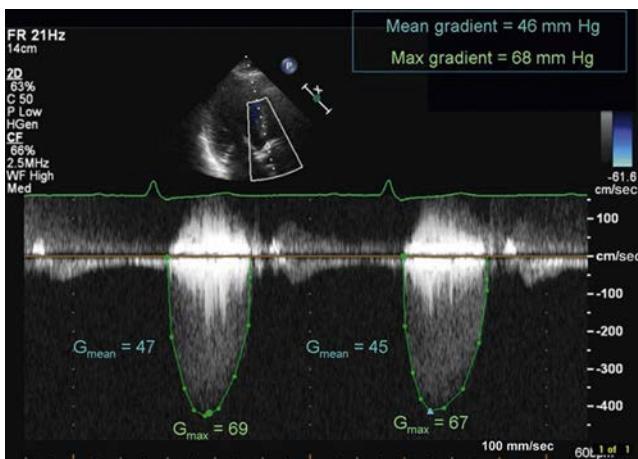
Quantification of the degree of aortic stenosis with continuous Doppler. G_{max} , Maximum gradient; G_{mean} , mean gradient. (From http://web.stanford.edu/group/ccm_ecochardio/cgi-bin/media_wiki/index.php/Aortic_stenosis_assessment. Accessed August 21, 2014.)
